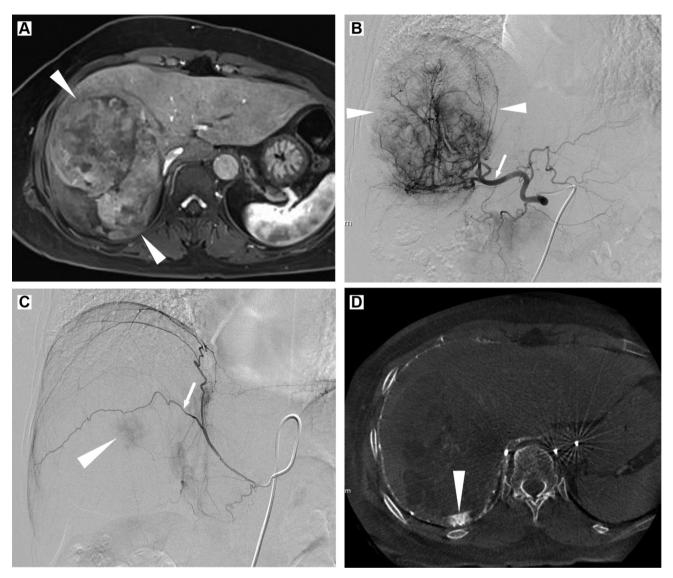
A 64-year-old woman with hepatocellular carcinoma. (A) Axial MR image shows an 11.3 cm sized hypervascular tumor (arrowheads). (B) Common hepatic angiogram shows a large tumor blush (arrowheads). A total of 15 GBq of 1st week dosing was administered at the right hepatic artery (arrow). (C) Right inferior phrenic angiogram shows a small tumor blush (arrowhead). A total of 3 GBq of 2nd week dosing was administered at the posterior branch (arrow) of right inferior phrenic artery. (D) Axial image of cone-beam CT obtained at the right inferior phrenic artery confirms the presence of tumor part (arrowhead) supplied by the right inferior phrenic artery.
